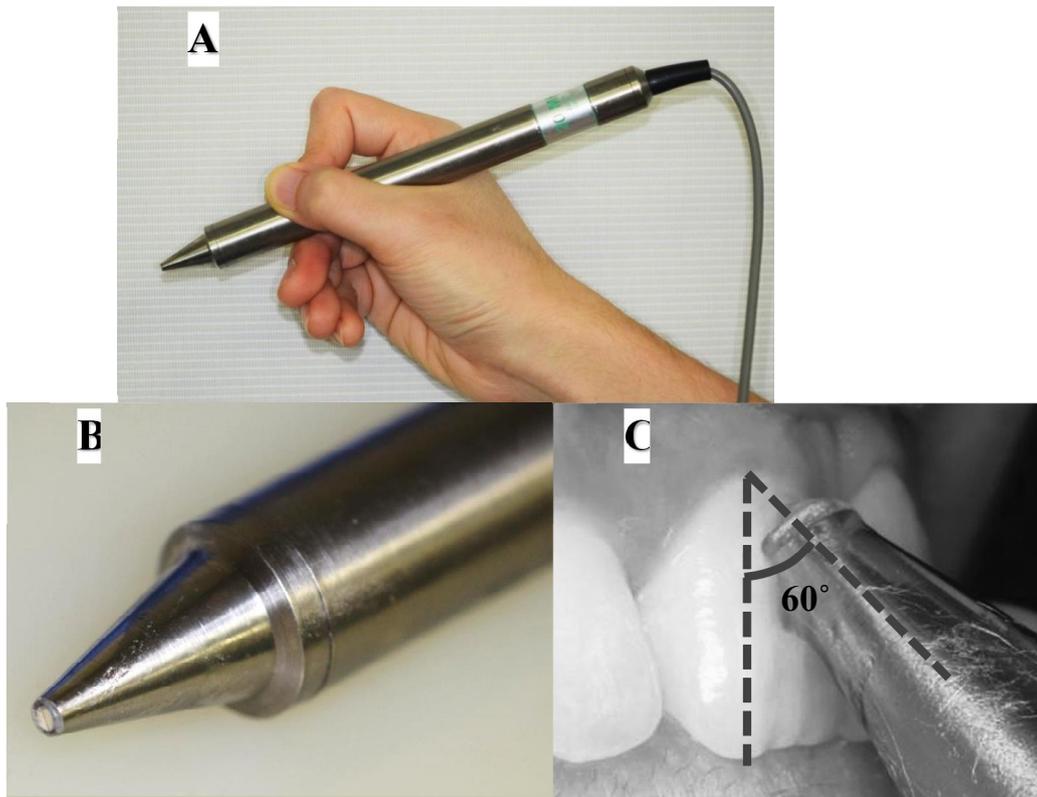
Ultrasonic probe of the Minimax Doppler machine
